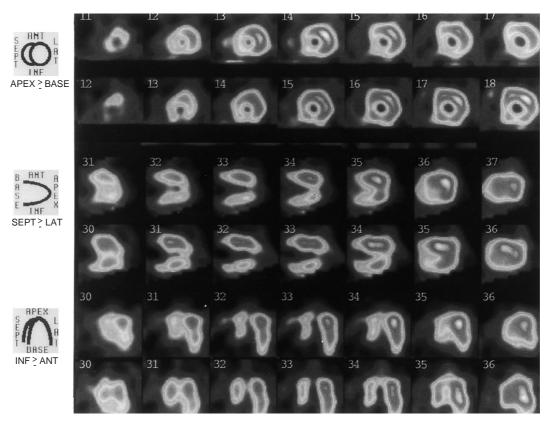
Resting thallium-201 myocardial scintigrams showing a myocardial perfusion defect in the left ventricular apex
